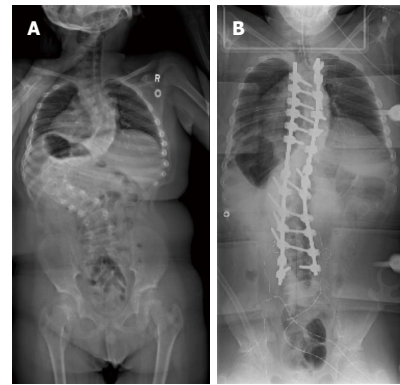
A-P X-ray of the patient. A: Preoperative A-P X-ray of the patient with severe scoliosis, Cobb angle 128 degrees; B: Postoperative A-P X-ray showing spinal instrumentation and final correction.
